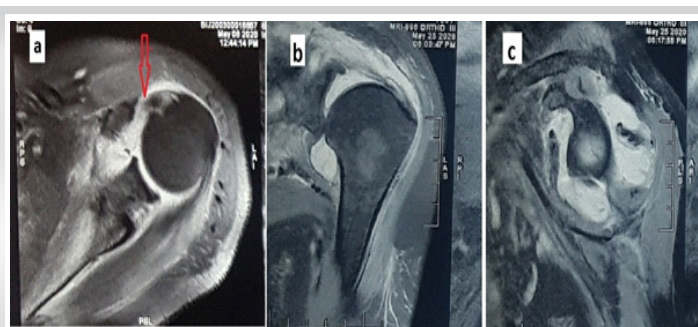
Magnetic resonance imaging (a-axial, b-coronal c-sagittal) images showing hyperintense signals suggesting severe effusion inside the joint secondary to capsulitis along with partial tear of the upper third subscapularis muscle (red arrow) and shoulder subluxation.
